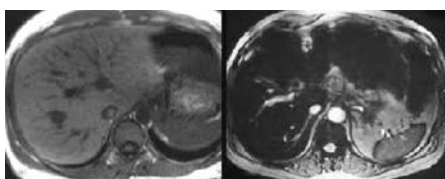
GRE sequences can produce images with either T1 or T2* weighting. Short TEs and high FAs generate T1-weighted images (FMPSGR TR 160, TE 4.4, FA 80) left, while longer TE's and lower FAs generate T2-weighted images (TR 50, TE 30, FA 20) right.
